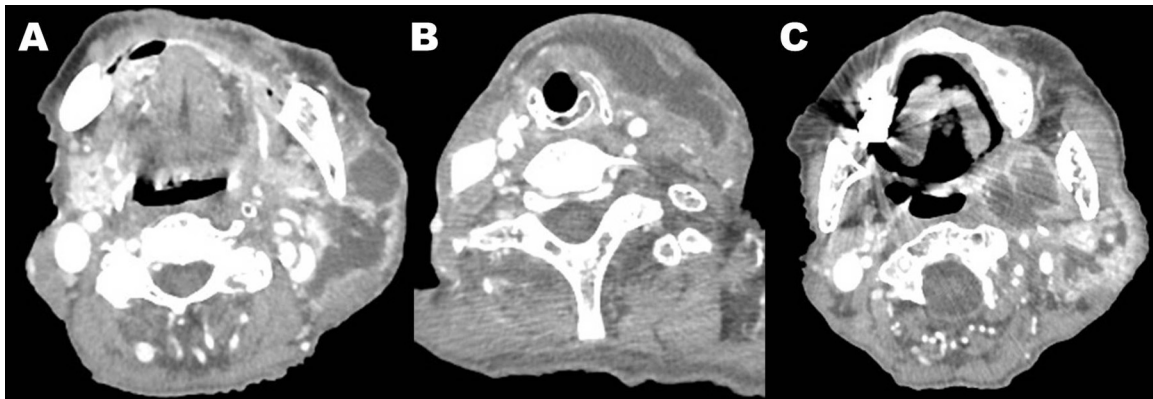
CT shows the extent of the abscess, arising from the left parotid gland (A) and spreading to the whole left neck over the sternocleidomastoid muscle (B) and inside the internal pterygoid muscle (C).
